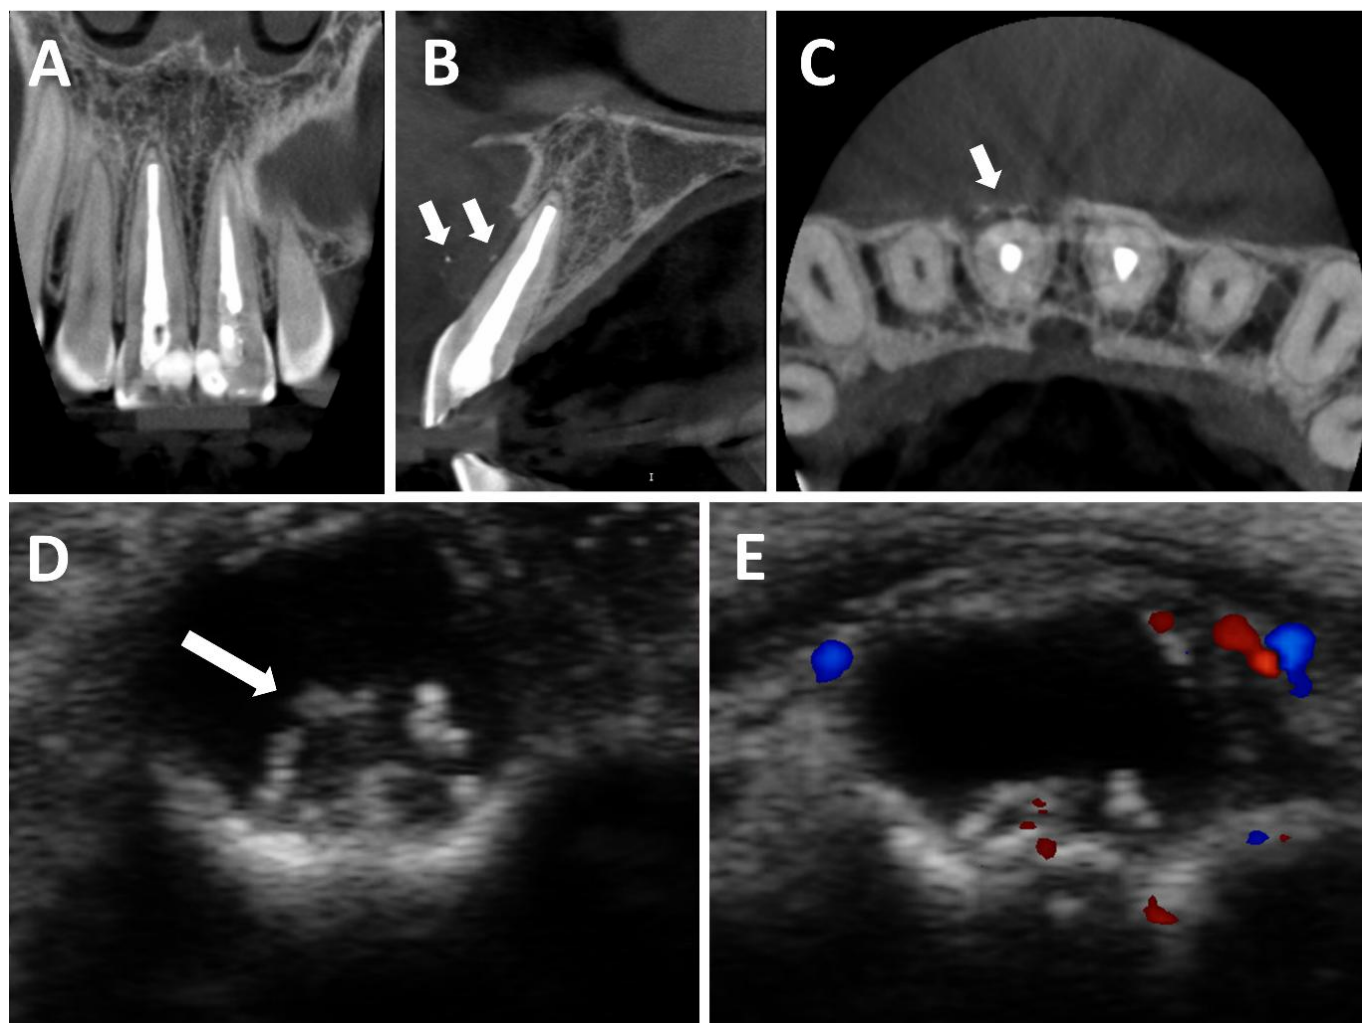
Coronal CBCT slice showing normal apical tissue in the maxillary central incisors (A). Sagittal and axial CBCT slices showing buccal bone loss in the coronal and middle thirds of the root of the maxillary right central incisor, associated with a hypodense unilocular lesion with a diffuse sclerotic rim and sparse hyperdense flecks (arrows) (B and C). Ultrasonographic image showing an unilocular, anechoic lesion with subtle posterior acoustic enhancement, well-defined contours, superficial boundaries in the oral mucosa, and hyperechoic debris or fragments (arrow) within the lesion (D). Color Doppler imaging shows absence of internal vascularization and presence of peripheral vascularization in the more superficial portion of its contour (E).
